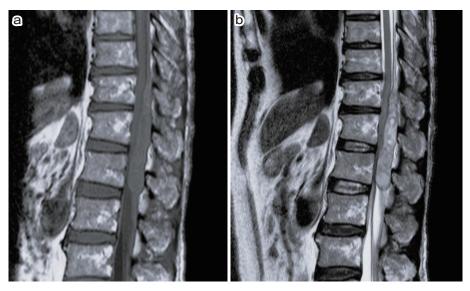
a, b: Magnetic resonance imaging demonstrates a well-circumscribed posterior epidural mass at the T10-L2 level measuring 110 mm × 18 mm × 12 mm compressing the adjacent segment of the spinal cord. It elicits isointensity to the spinal cord on the T1-weighted image (Fig. 1a) and heterogeneous high intensity on the T2-weighted image, which is consistent with spinal epidural hematoma in the acute phase.
